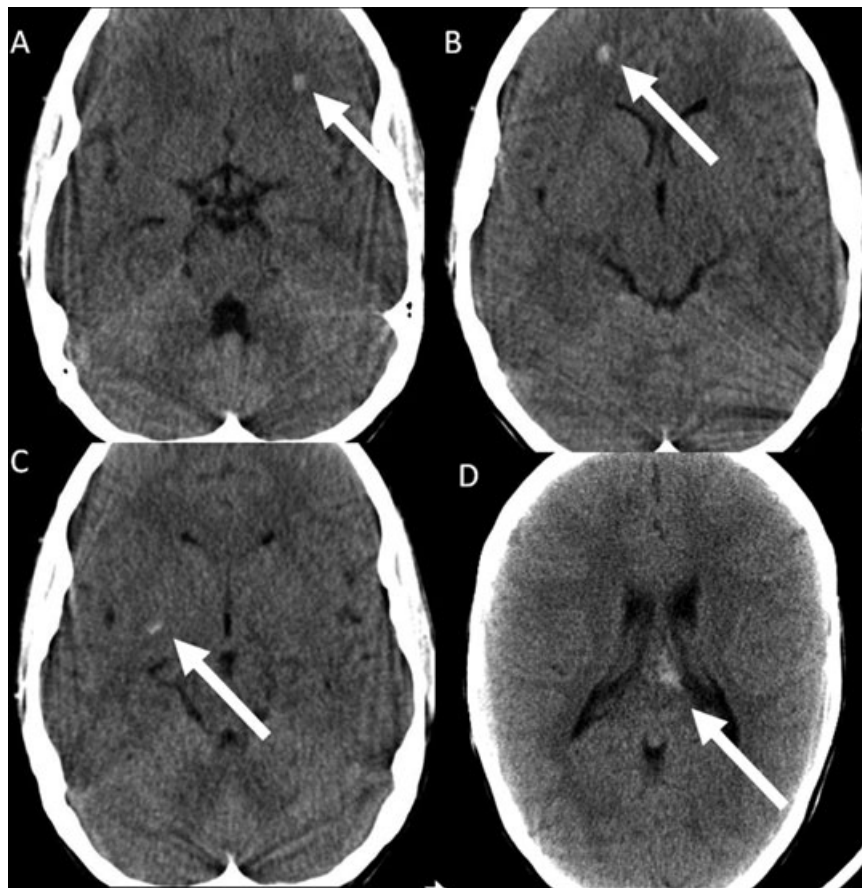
Axial CT images (A–D) of a 9-year-old girl who suffered extensive shear injuries because of a high speed MVA. Hyperdense shear injuries (arrows) are noted at the cortico–medullary junction within both hemispheres as well as along the right cortico–spinal tract within the internal capsule. In addition, significant shear injury is seen within the trunk and splenium of the corpus callosum.
